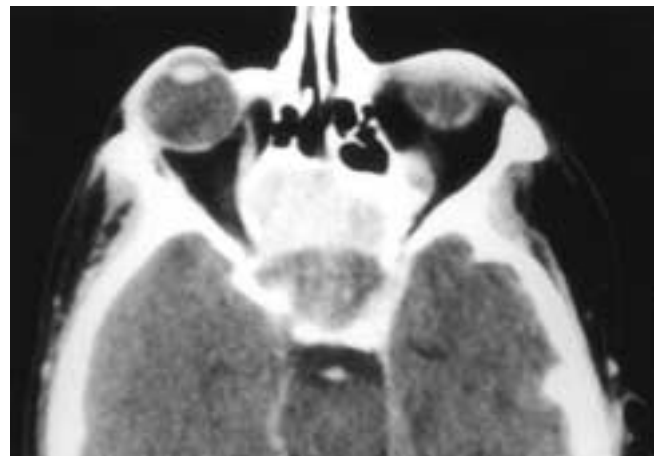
Axial CT scan shows an enhancing expansile mass in the posterior ethmoid sinuses. The sphenoid sinuses are obstructed with lower-attenuation secretions. Some bone remodeling is also present in the lamina papyracea. This patient had a mucoepidermoid carcinoma and a sphenoid mucocele.
